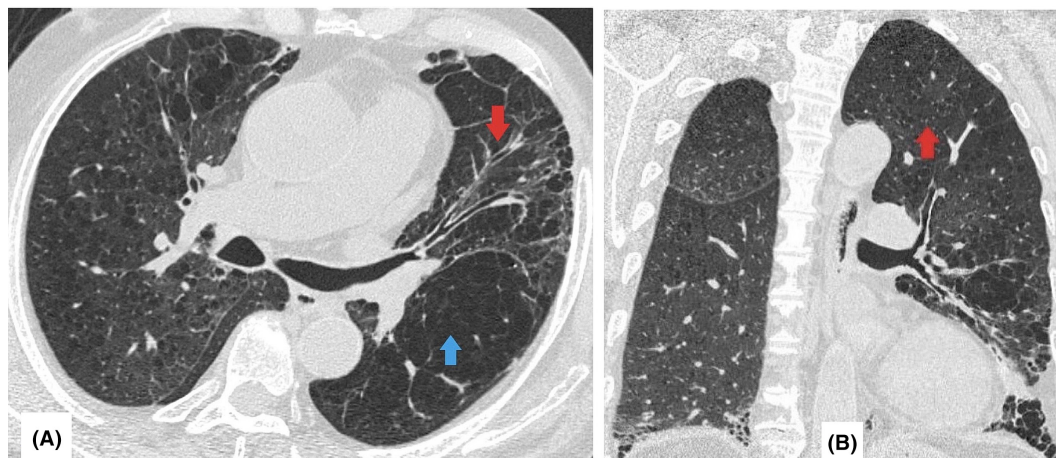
(A) Axial computed tomography (CT) section in lung window at the level of left upper lobe bronchus. The foreign body (FB) is not present. Left upper lobe is inflated (red arrow). (B) Coronal CT section in lung window at left upper lobe bronchus level. The FB is not visualized. Left upper lobe is inflated (red arrow).
